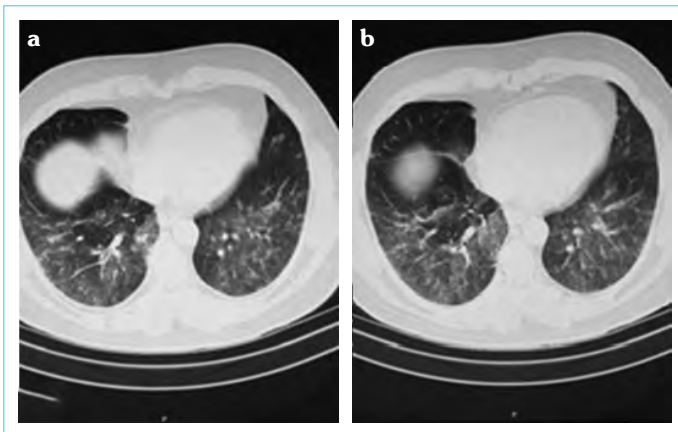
Pneumonic infiltration and ground-glass areas in the bilateral inferior zones at thoracic CT
